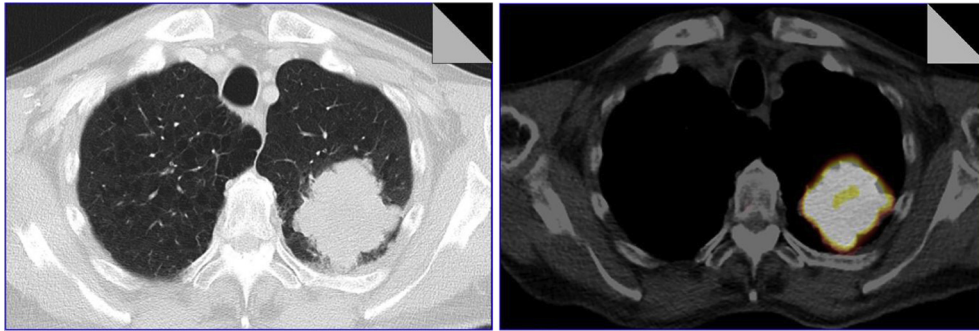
Blanco-CT and FDG-PET/CT of the thorax showing a circular mass at the dorsal side of the left upper lobe with a diameter of 7.4 cm.
